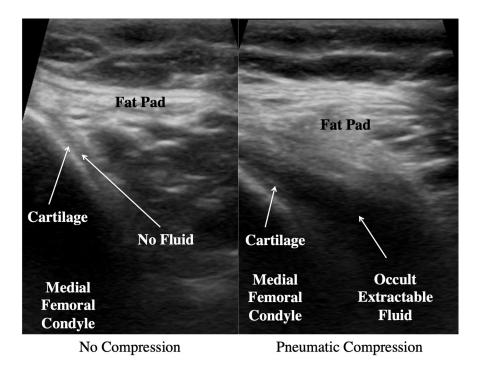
Ultrasound Image of Non-Effusive Knee with and without Pneumatic Compression (medial knee). The figure on the left is the flexed non-effusive knee, where the needle (Needle) cannot access the synovial fluid because the fat pad (Fat Pad) forces fluid from the surface of cartilage to the superior knee (Cartilage). The figure on the right is non-effusive knee with the pneumatic compression that compresses the suprapatellar bursa and inducing collapse driving the occult synovial fluid (Occult Extractable Fluid) inferiorly where the fluid collects over the cartilage surfaces (Cartilage) of the medial femoral condyle (Medial Femoral Condyle) displacing the fat pad (Fat Pad). The synovial fluid (Occult Extractable Fluid) can then be accessed by the needle (Needle).
